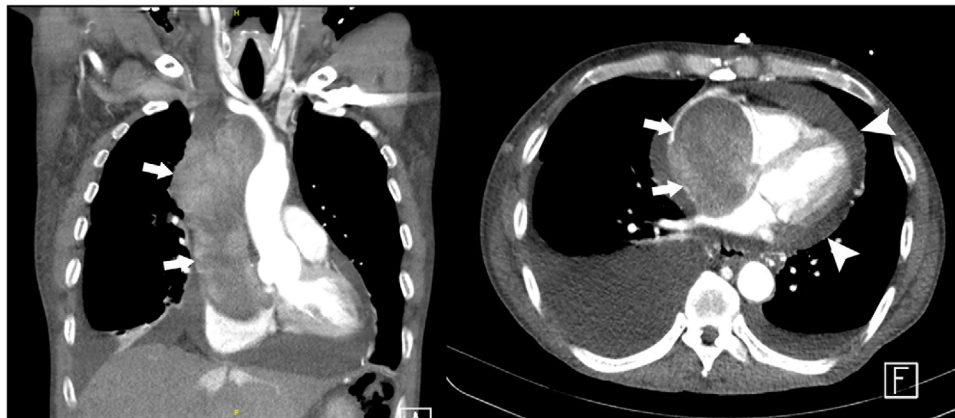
Coronal (left panel) and axial (right panel) contrast-enhanced computed tomography scan of the thorax showing the right atrial mass (arrows) with invasion into the superior vena cava. Pericardial effusion is seen (arrowheads)
